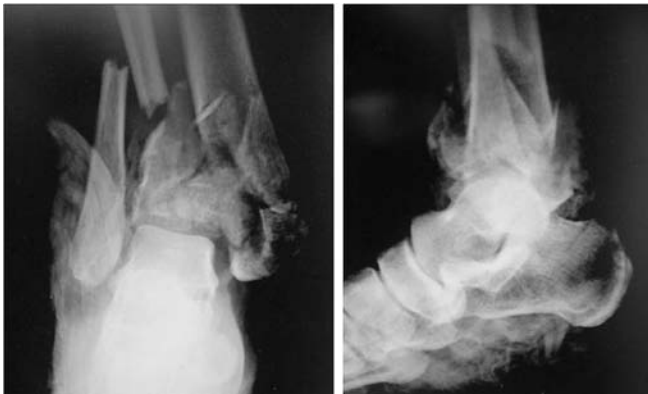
AP and lateral radiographs prior to surgery.
